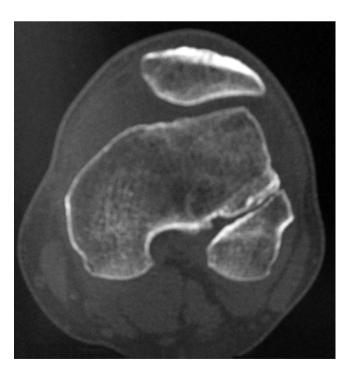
Axial CT image demonstrating ideal positioning of ACL femoral tunnel in this plane. Note the tunnel centered on the cut in which the notch resembles a Roman arch
